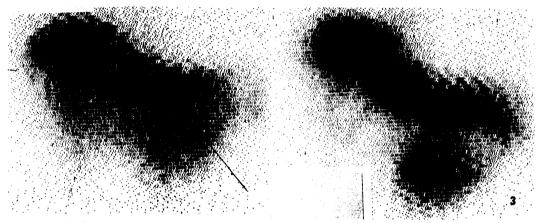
Liver scintigrams in Case 1. The left, 52nd day and the right, 136th day.
